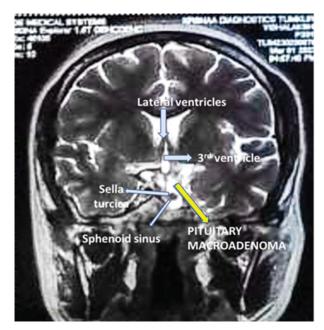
Coronal and sagittal contrast-enhanced MRI scan showing sellar and suprasellar pituitary macroadenoma.
